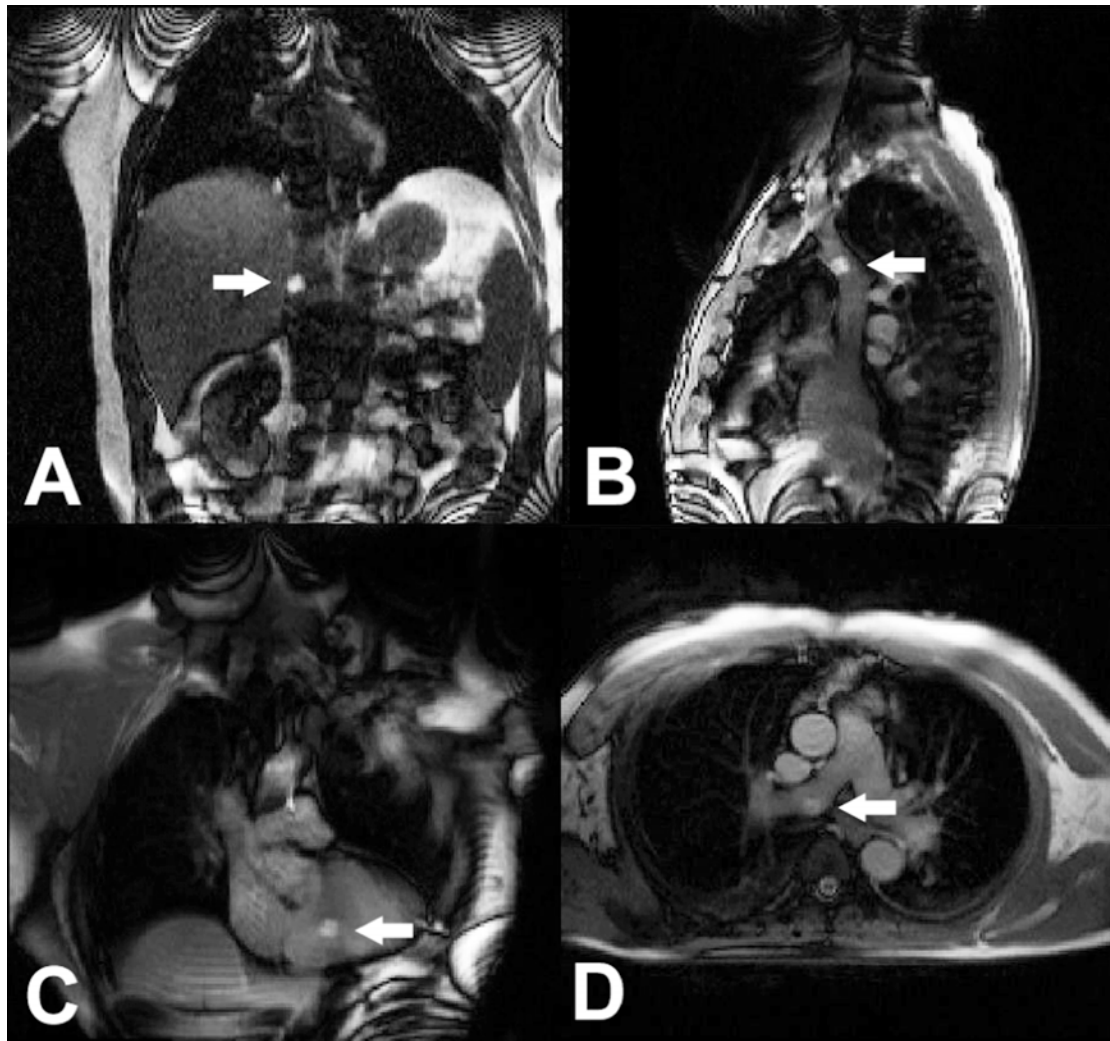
MRI guided right heart catheterization
